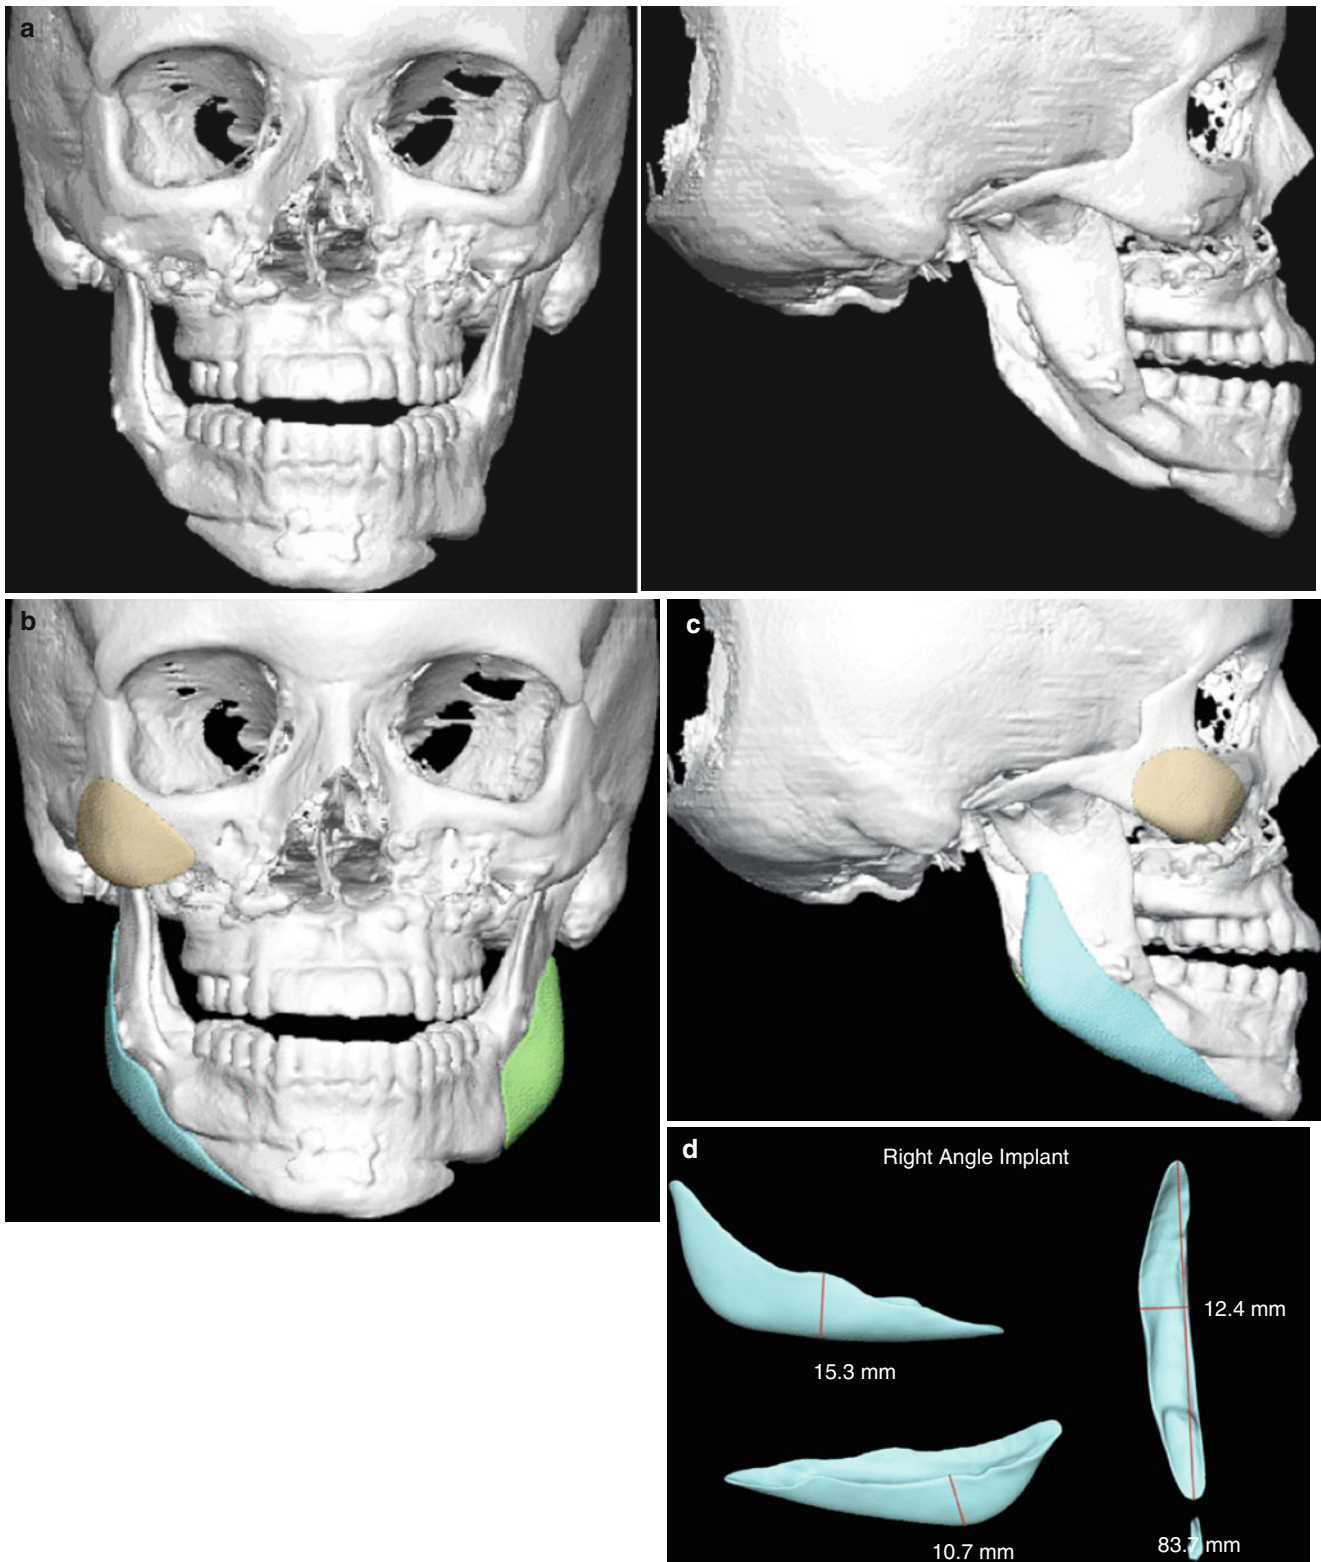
CT demonstrates postoperative change following orthognathic surgery (LeFort 1, BSSO, osseous genioplasty) in an 18-year-old female with craniofacial microsomia. (a) Note expected residual complex asymmetries despite achieving the planned orthognathic result. (b, c) Virtual planning based on mirror imaging demonstrates spatial forms
